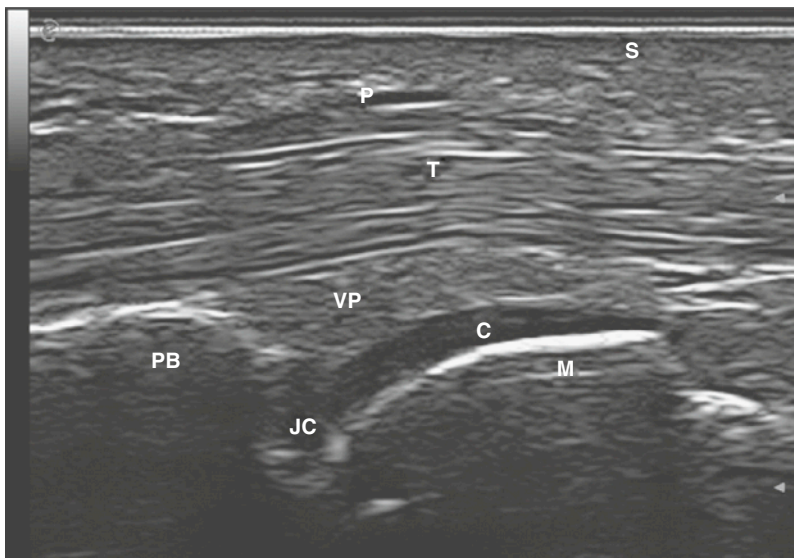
VOLAR ASPECT OF THE METACARPOPHALANGEAL JOINT. Ultrasound shows the volar aspect of the metacarpophalangeal joint in the sagittal plane. C, hyaline cartilage; JC, joint cavity; M, metacarpal head; P, pulley; PB, phalangeal base; S, skin; T, flexor tendon; VP, volar plate.
